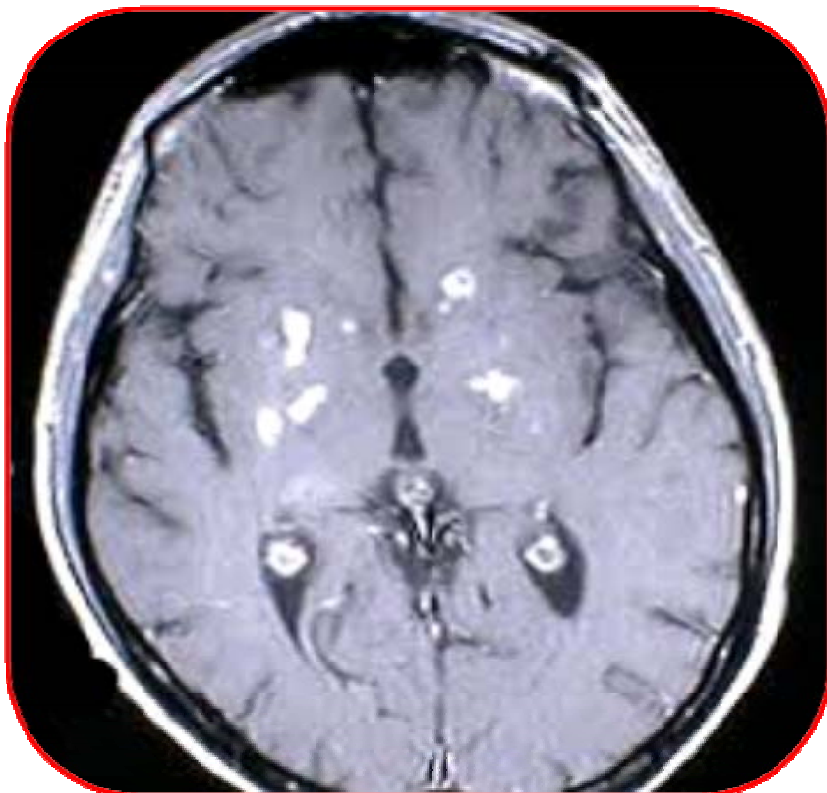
Cryptococcal meningoencephalitis. A computed tomographic section through a brain of patient with meningoencephalitis (med.uc.edu)
